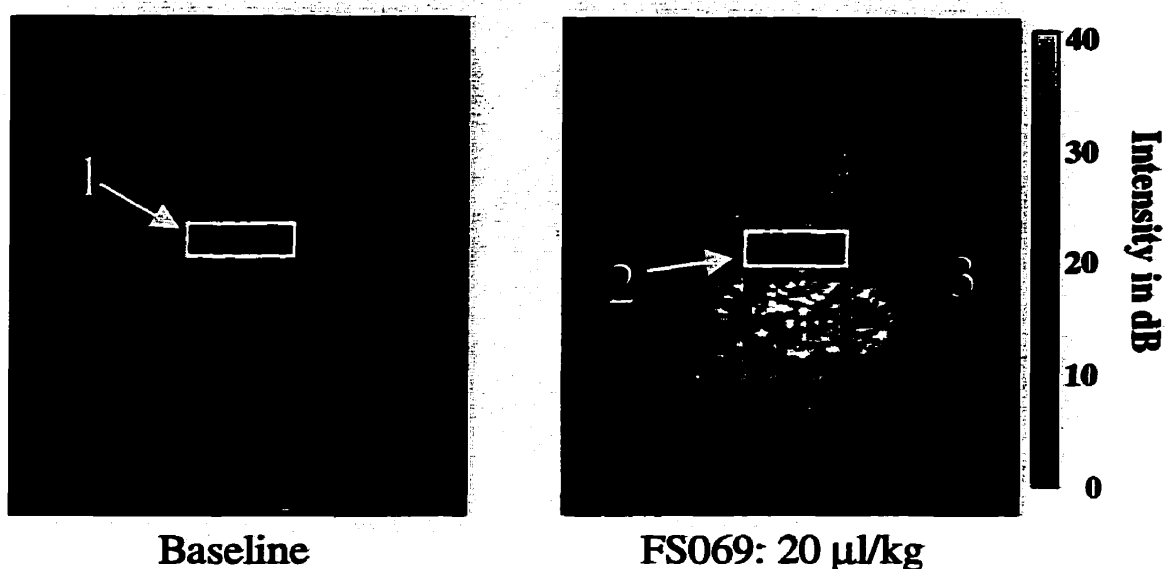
Reconstructed right parasternal short axis views of the heart before and after a 0.3 ml bolus injection of Optison (maximum depth: 11.7cm). From such images, echoes from tissue alone (1), perfused tissue (2), and agent alone (3) may be isolated for analysis.
